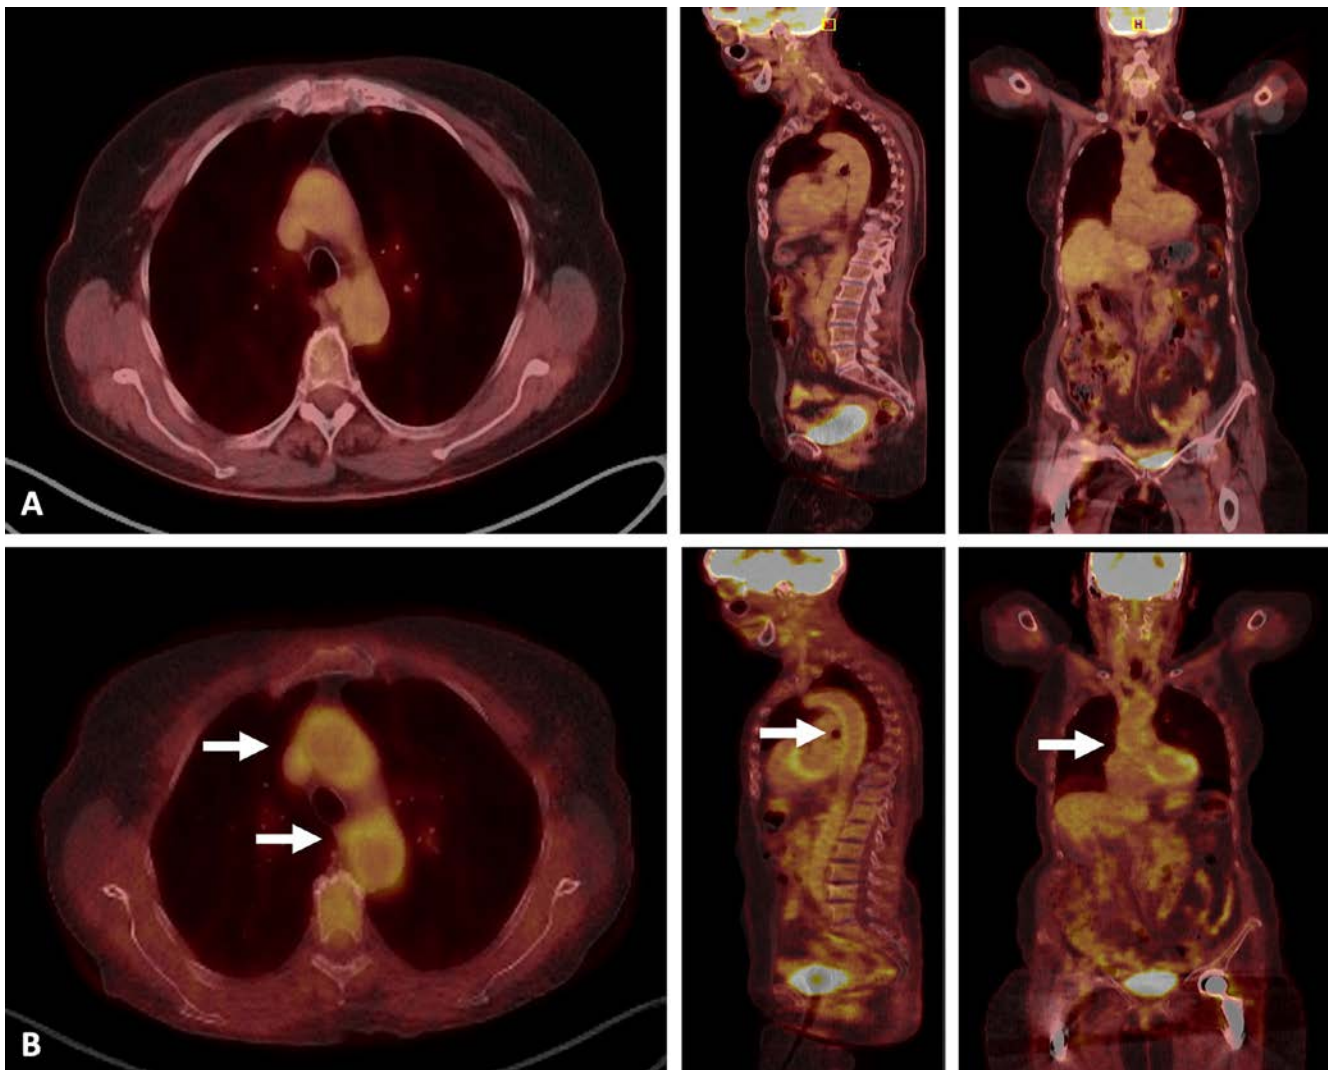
Large vessel vasculitis relapse in a patient with GCA. Images show an 83-year-old woman with biopsy-proven GCA, whose disease onset was characterized by a three-week history of headache, scalp tenderness, jaw claudication, and constitutional symptoms. (A) Initial FDG PET/CT performed two days after the start of high-dose glucocorticoids (60 mg/day prednisone) showed no abnormal vascular or musculoskeletal uptake. (B) One year after diagnosis, the patient relapsed with daily headache, polymyalgia rheumatica symptoms, fever, and elevated acute-phase reactants. PET/CT demonstrates avid uptake of FDG in the ascending and descending aorta (arrows) as well as in the carotid arteries. Axial, sagittal, and coronal views are presented. FDG, [^{18}F]-fluorodeoxyglucose; GCA, giant cell arteritis; PET/CT, positron emission computed tomography.
